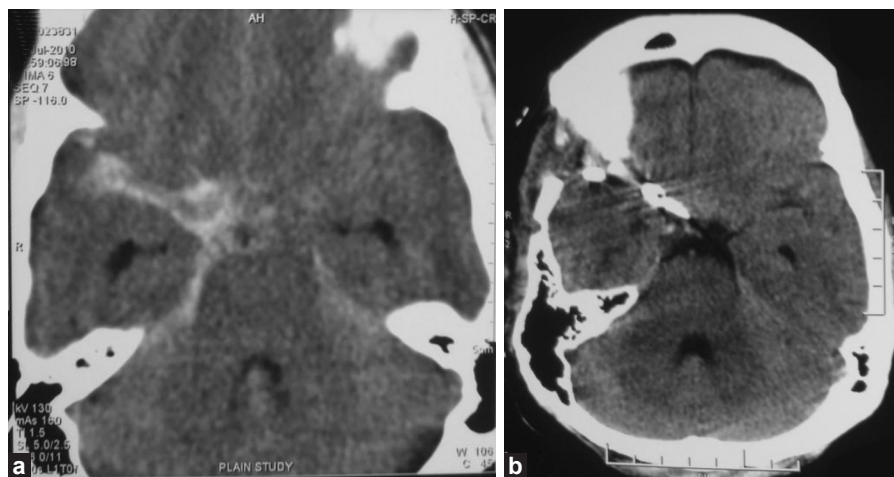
(a) Preoperative CT brain scan showing SAH in Rt. sylvian fissure and Rt. ambient cistern (b) CT brain scan showing clearance of subarachnoid blood (post-FLUX use)
